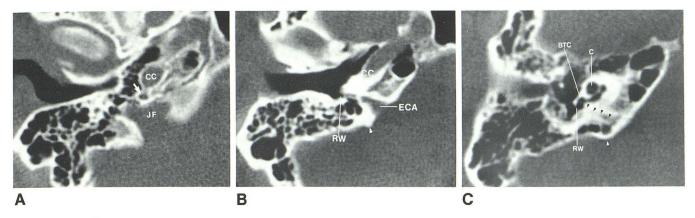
Axial CT scans of right temporal bone in patient from inferior to superior. A, Below cochlear aqueduct through carotid canal (CC) and jugular fossa (JF). Interposed between two structures is caroticojugular spine, occupied by widened tympanic canaliculus (arrow). B, Through external cochlear aqueduct (ECA). In this patient, aqueduct is patulous, forming wide funnel. Cochlear aqueduct is also enlarged, allowing better visualization of its course.
